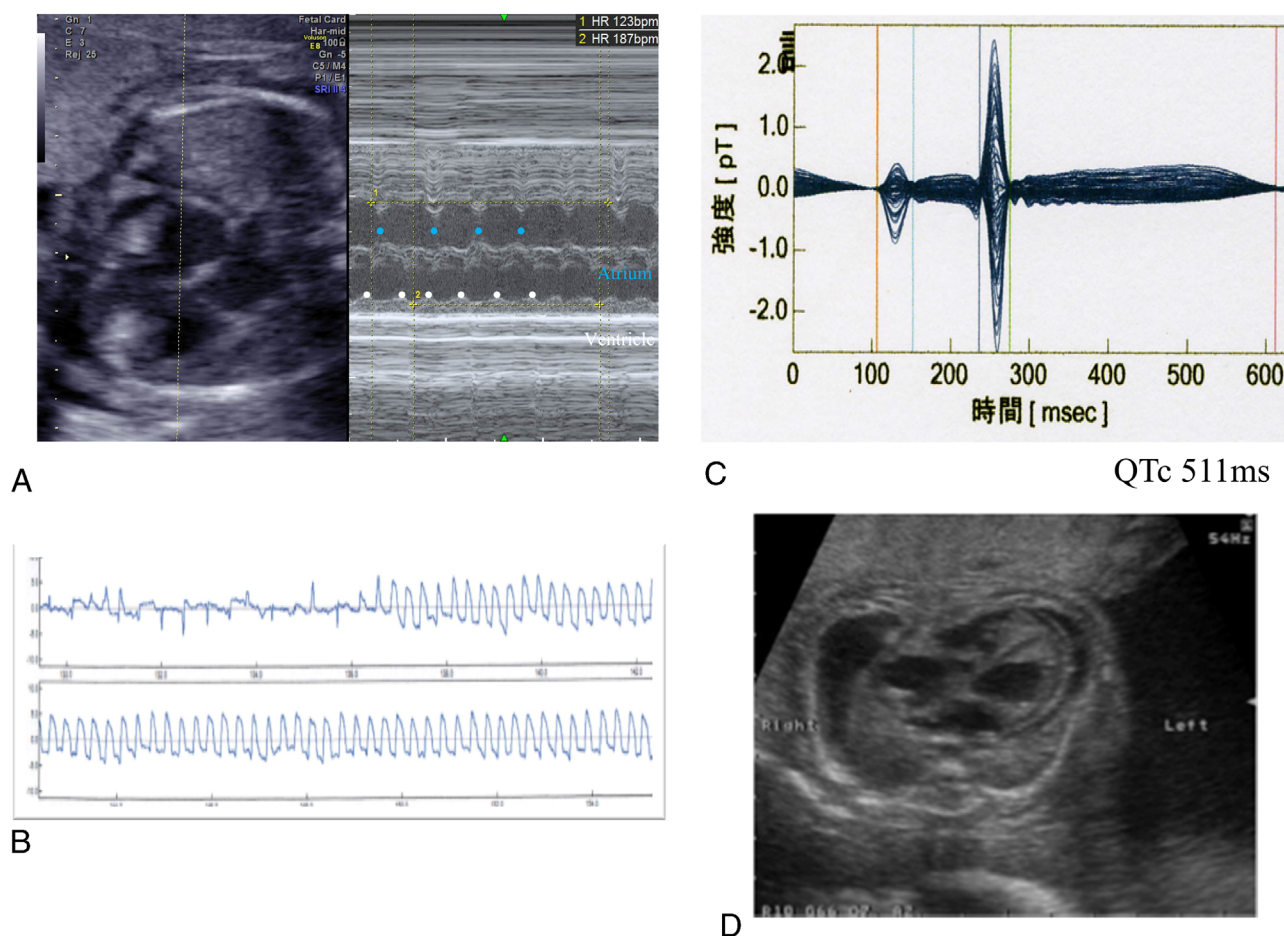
Case 2. A: At 24 weeks' gestation, the initial fetal echocardiography showed fetal ventricular tachycardia with a ventricular rate of 187 beats per minute (bpm) and an atrial rate of 123 bpm. B: Fetal magnetocardiography (fMCG) revealed sustained ventricular tachycardia with a V rate of 220 bpm. C: fMCG showed a prolonged QT interval (511 ms) during transient sinus rhythm. D: At this time, the fetus also developed ascites, skin edema, and pericardial effusion as symptoms of severe hydrops.
